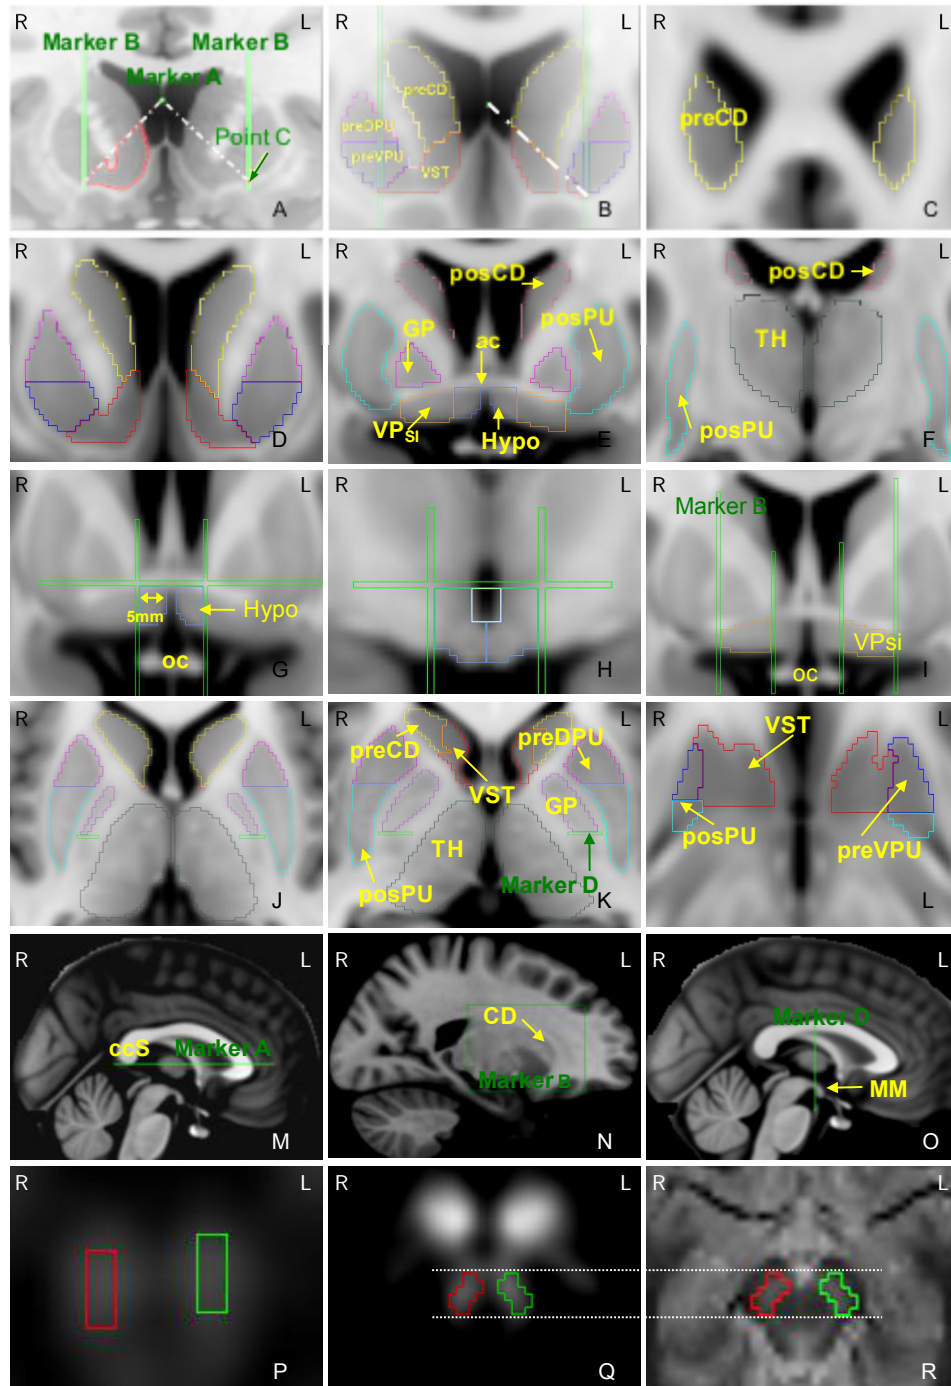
Guidelines for the manual delineation of subcortical ROIs on MRI (A-O) and substantia nigra/ventral tegmental area on PET (P-R) in a representative subject. R=right; L=left.
